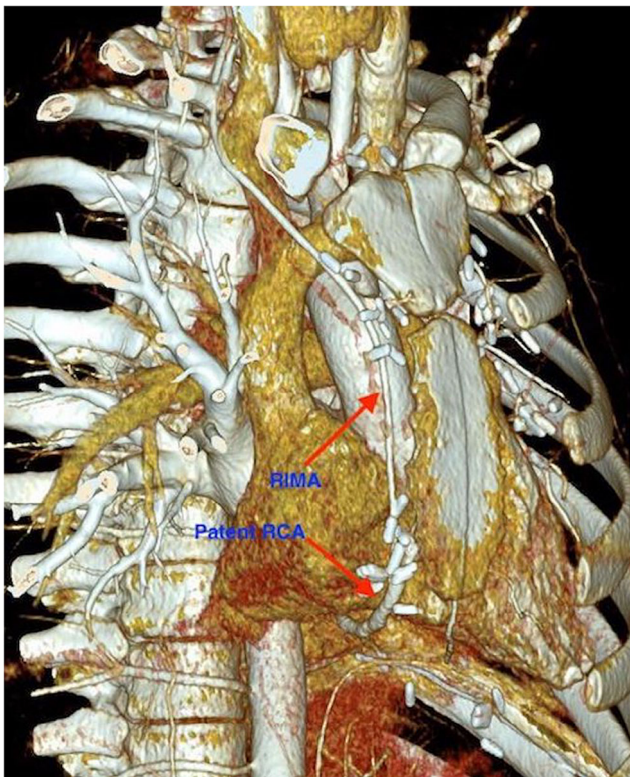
3D reconstructed postoperative CT angiogram showing patent RIMA-to-RCA anastomosis
